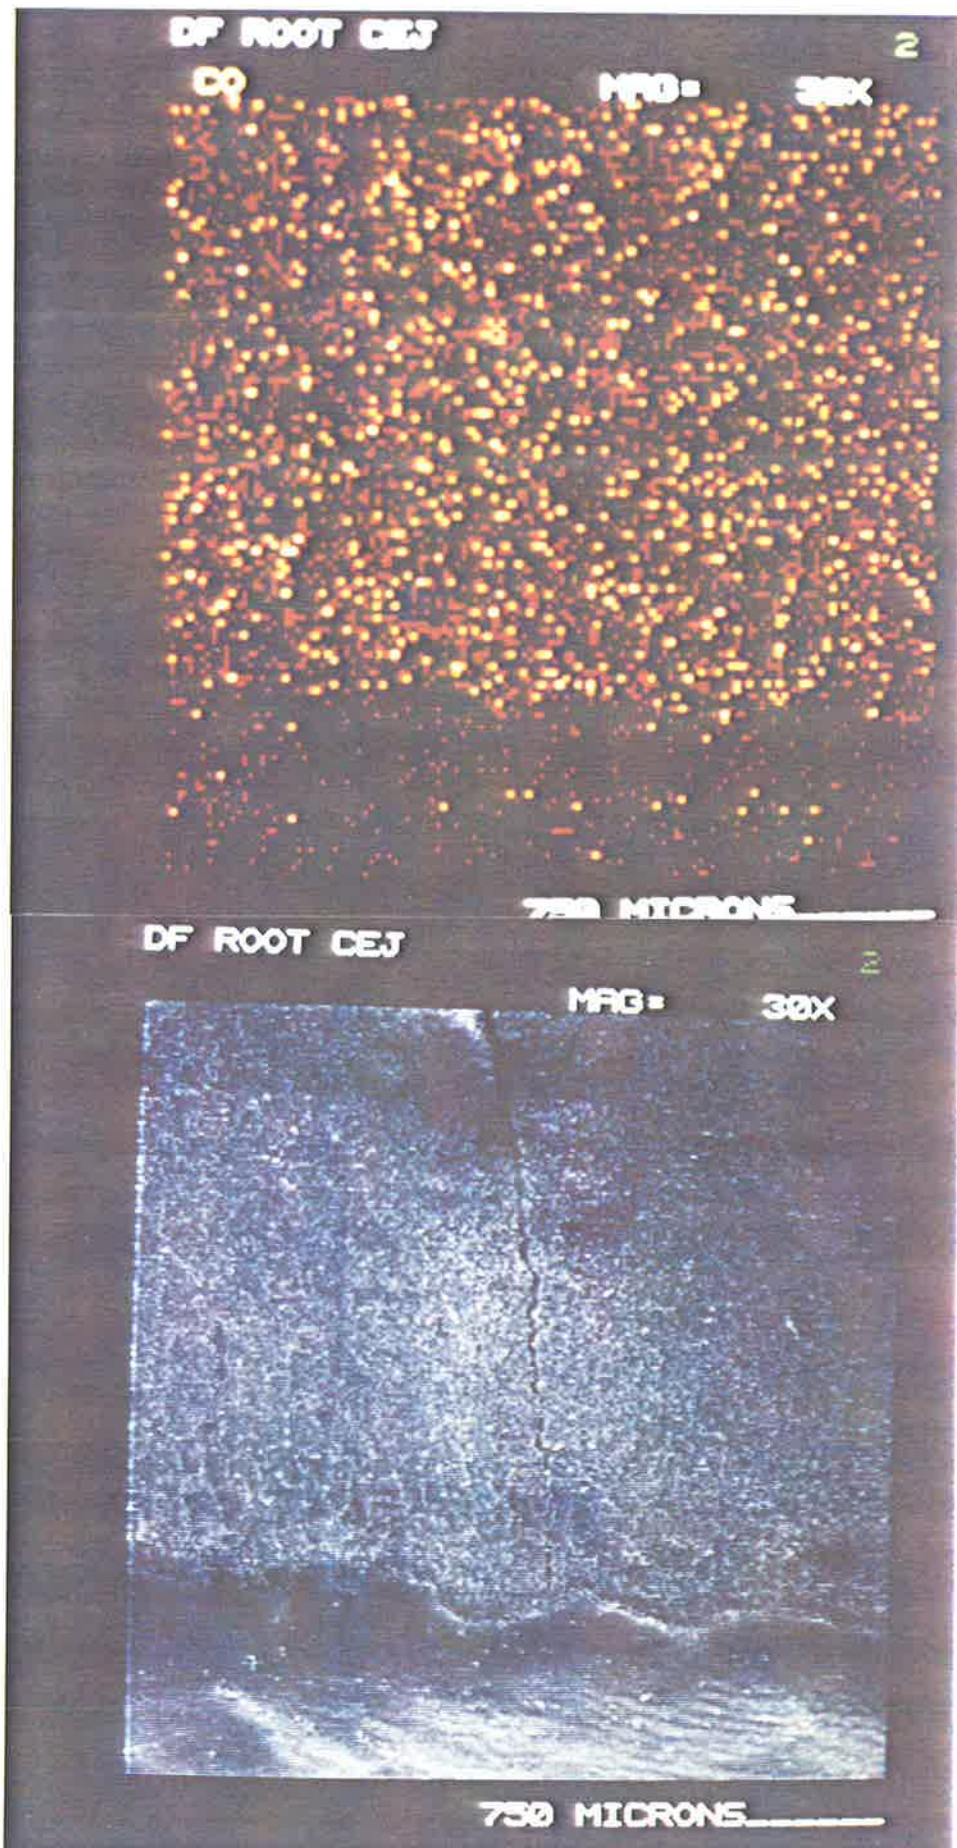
X-Ray Image Representing a Score of Three (SEM Image top).
